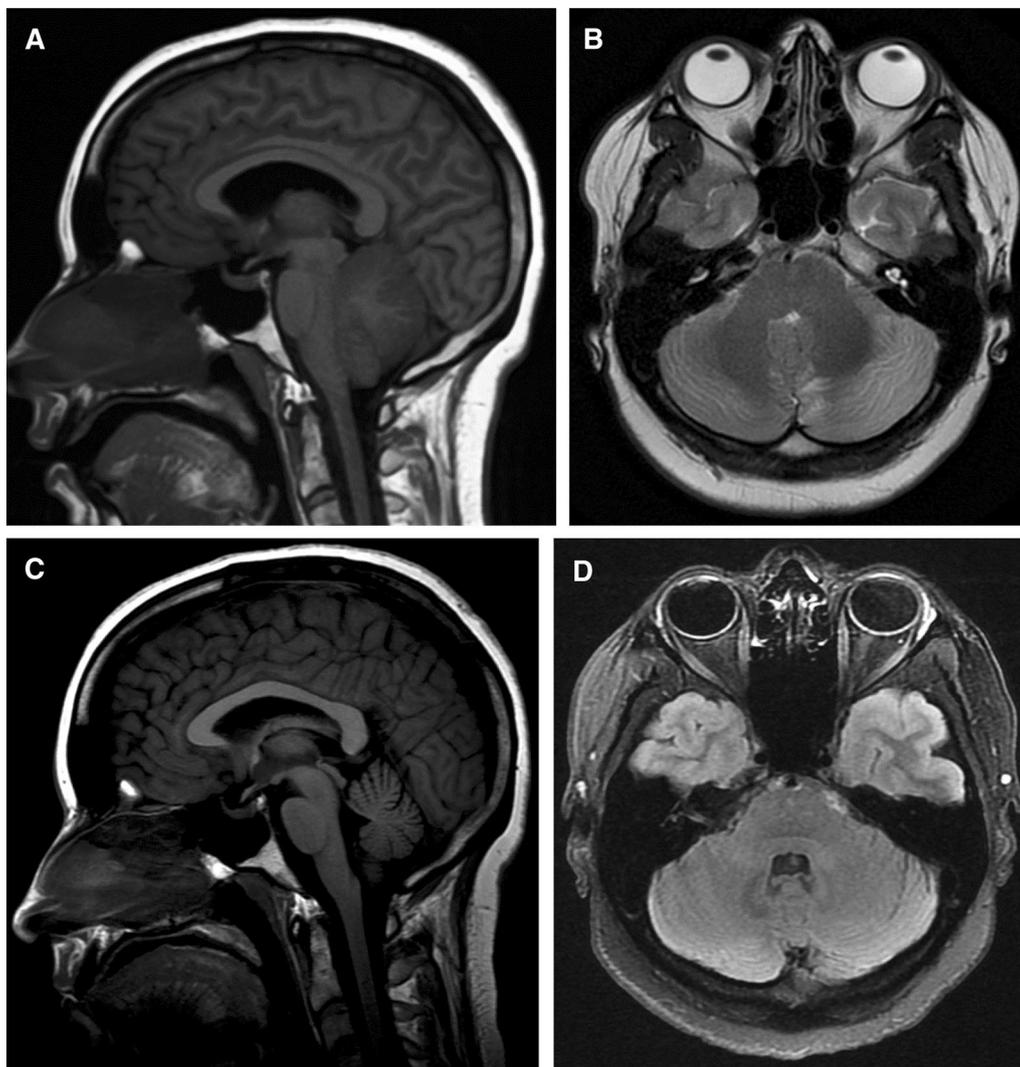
MRI scans. From left to right, up to down: a T1 sequence, showing hypointense, edematous cerebellar hemispheres with significant bowing of the pons, compression of the quadrigeminal plate and full obliteration of the aqueduct and 4th ventricle. b T2 sequence, showing hyperintense cerebellar hemispheres. c T1 fluid attenuated inversion recovery (FLAIR) showing atrophy of the cerebellar hemispheres. d T2 FLAIR sequence, showing normalized hyperintensity
